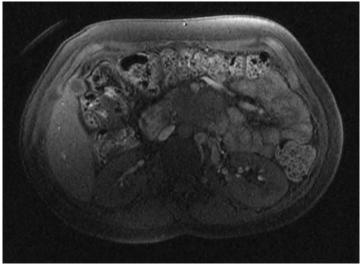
MRI showing the pre aortic mass
